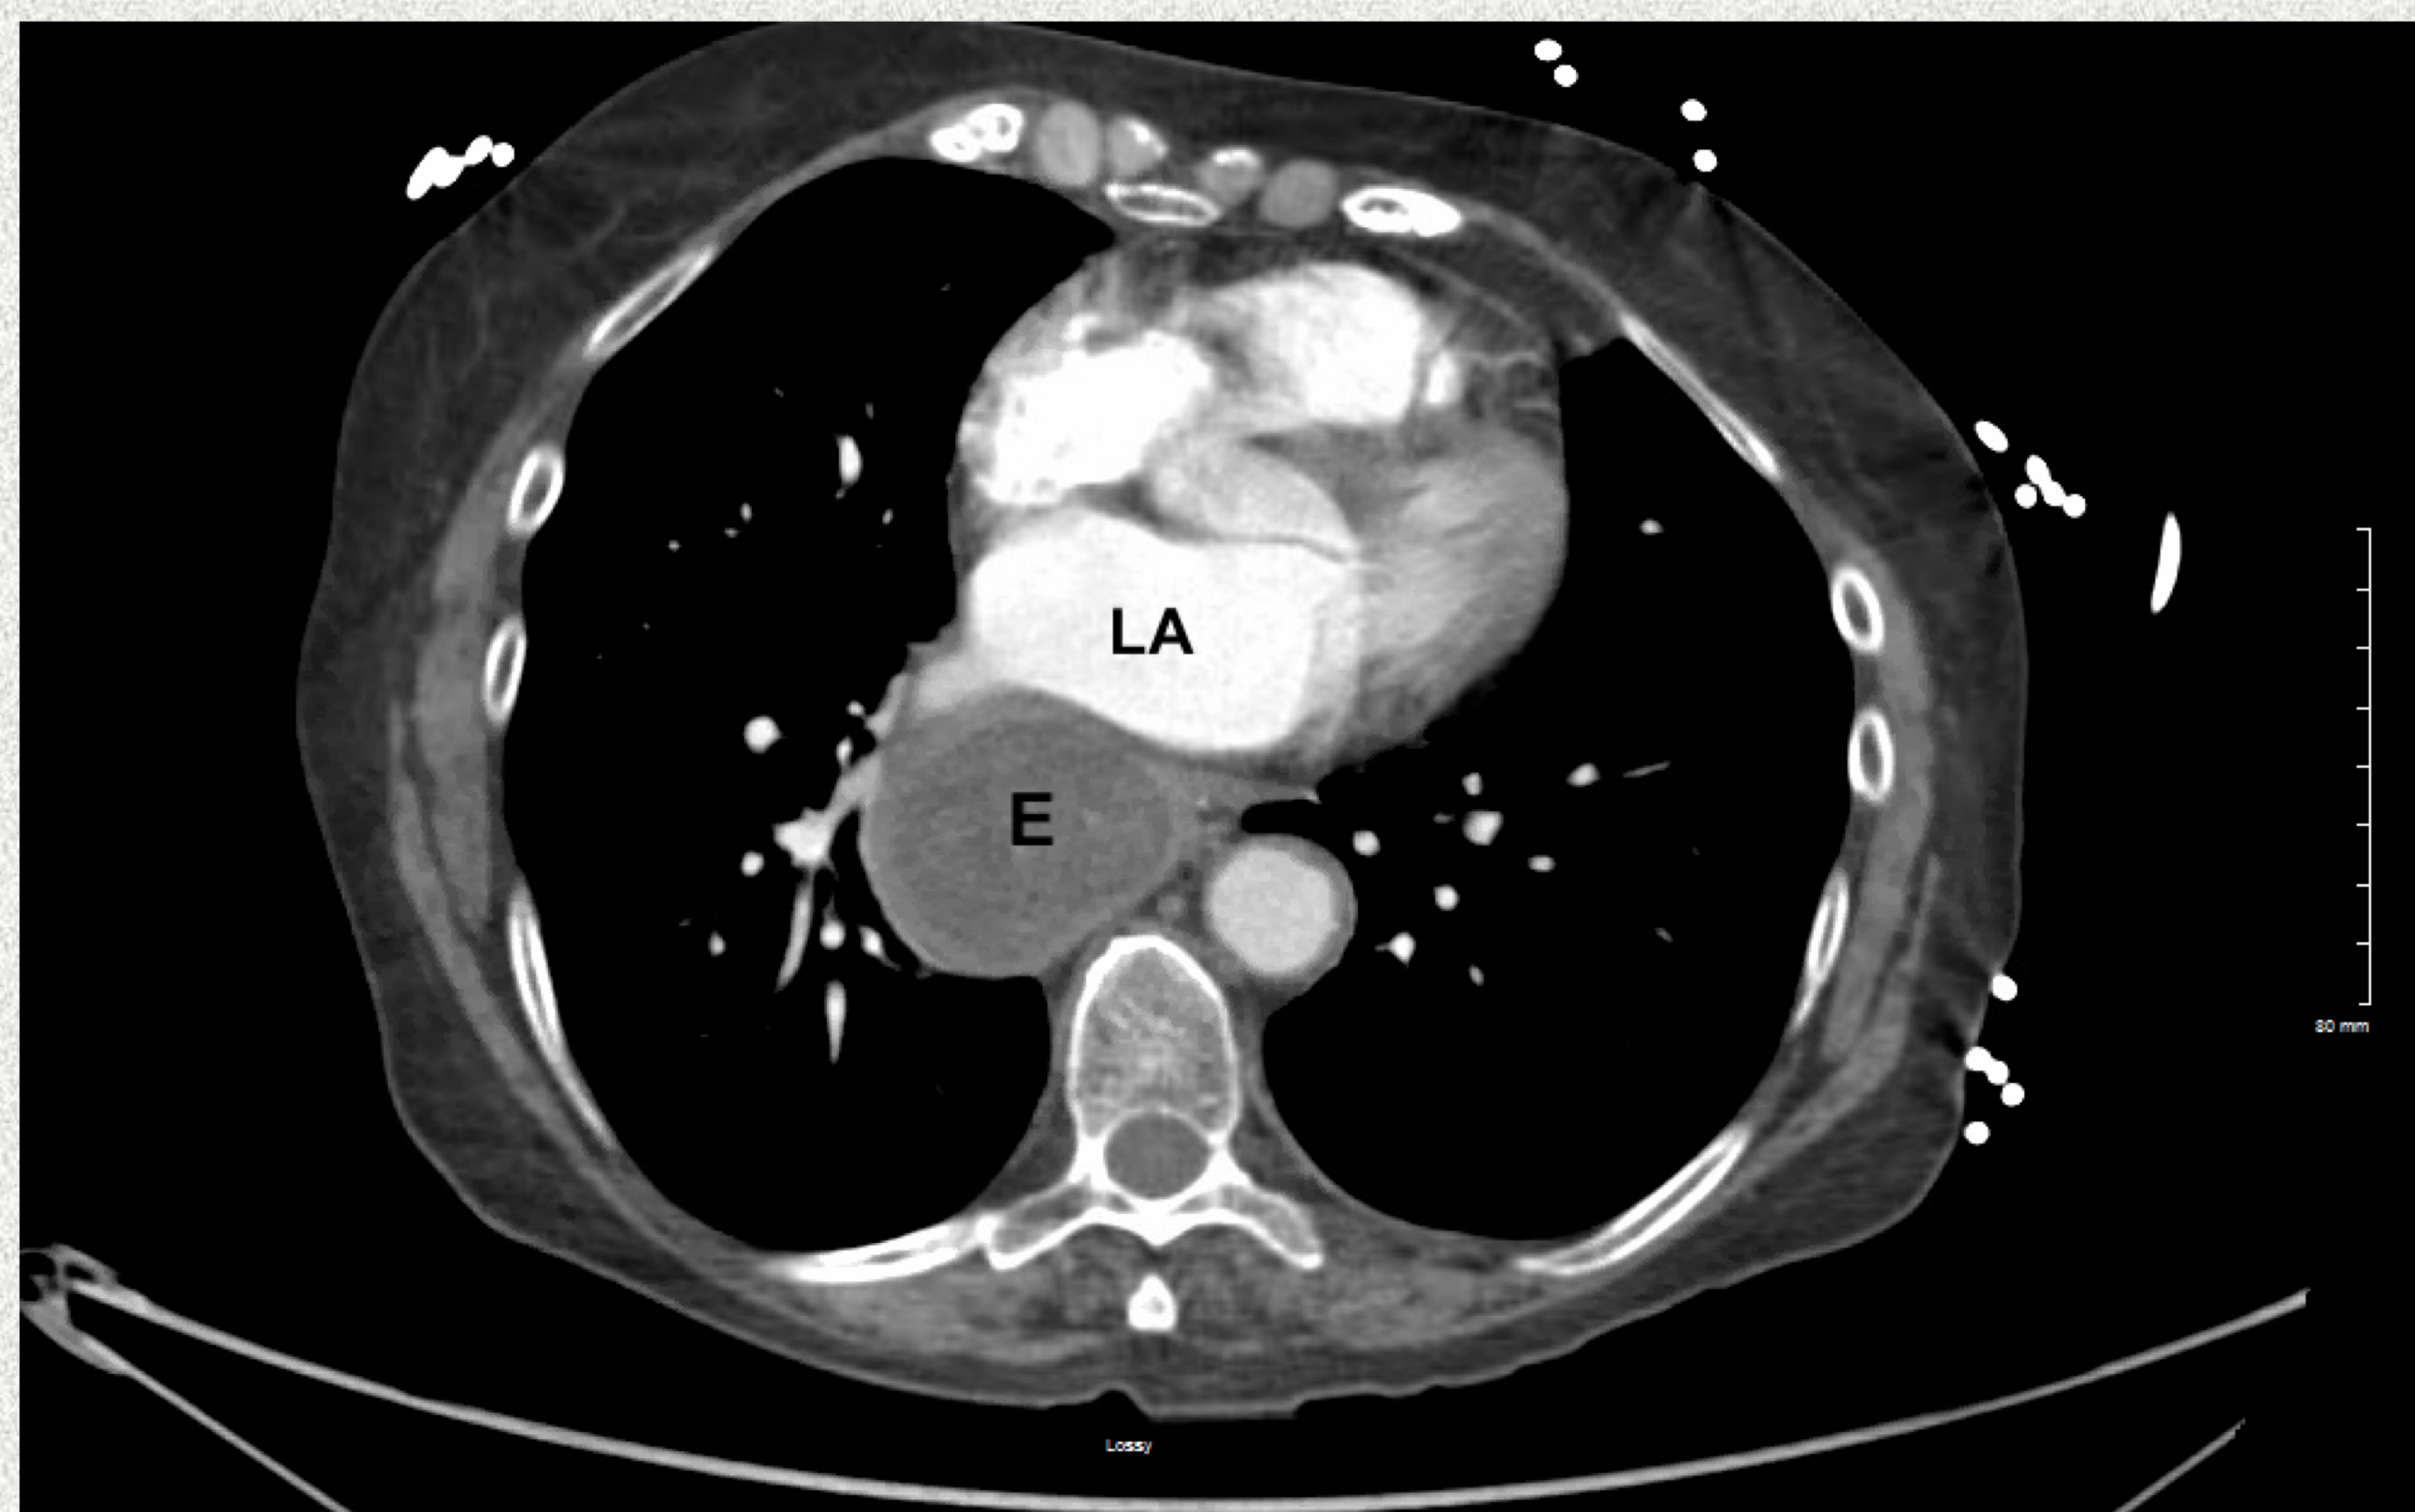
CT angiogram of chest and abdomen (axial view) showing dilated esophagus (E) compressing the left atrium (LA).
